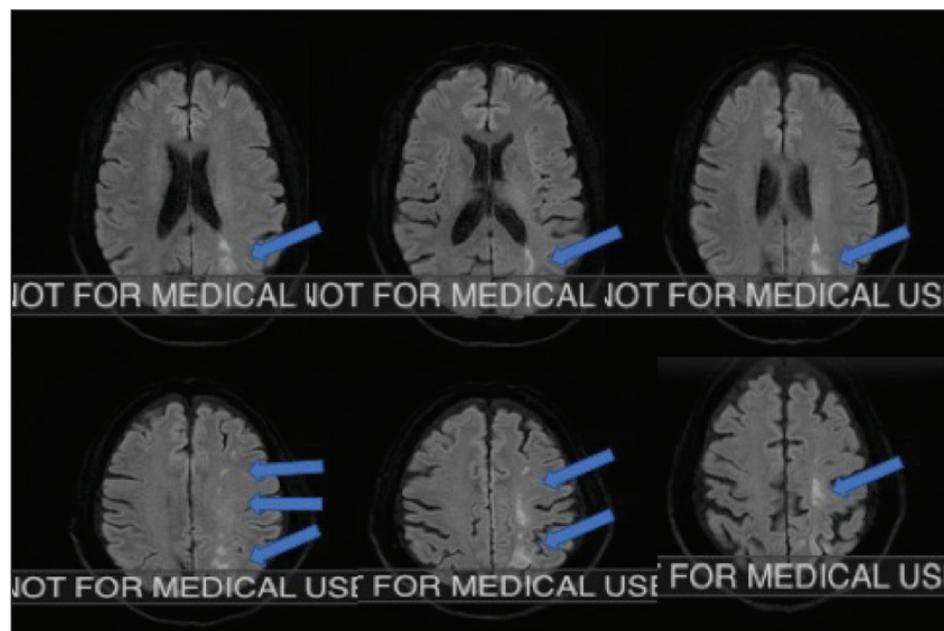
Diffusion-weighted MRI demonstrating the watershed infarct (blue arrows) in the left hemisphere.
